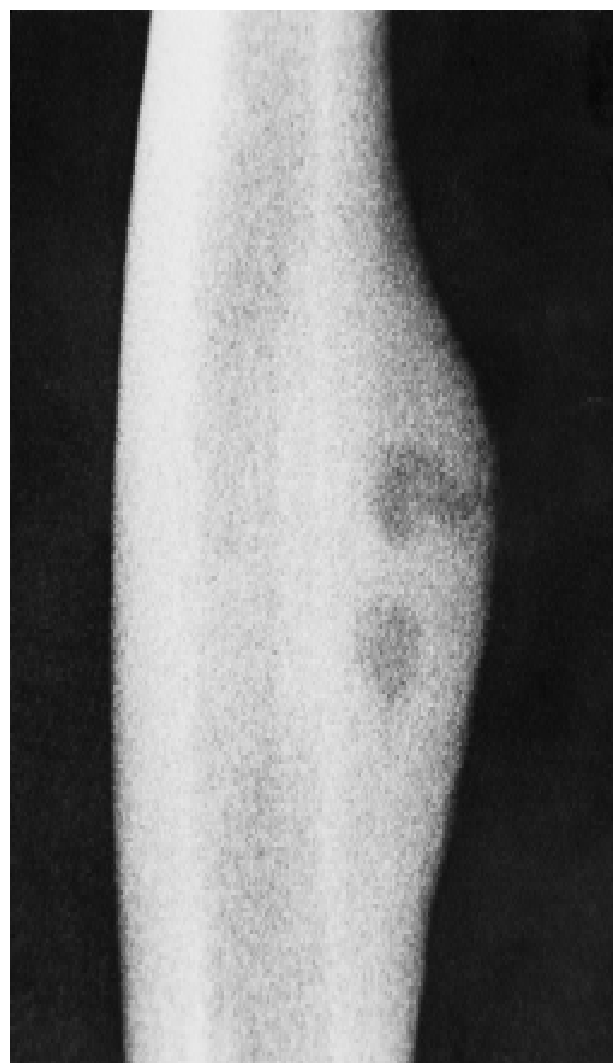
Radiograph humerus showing nidi and periosteal reaction.
